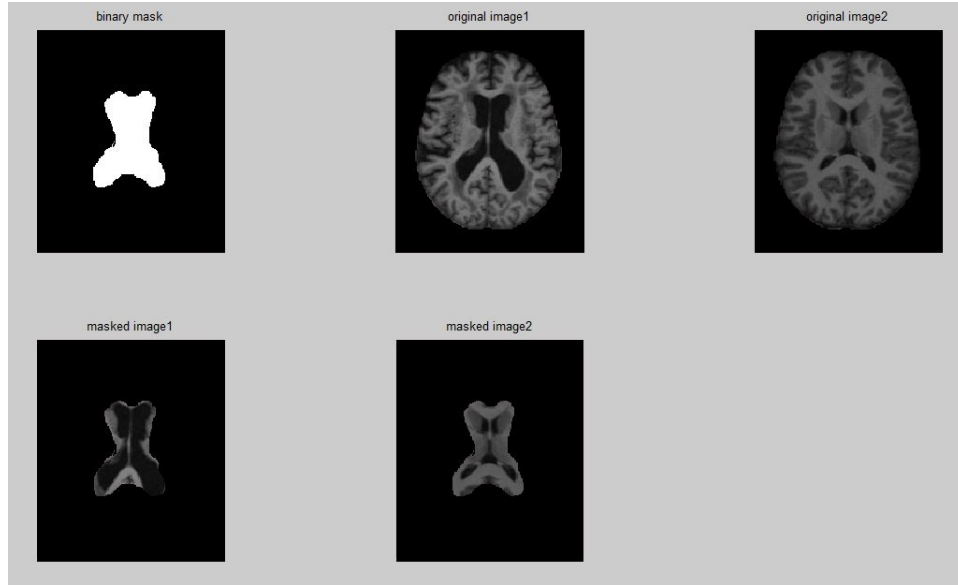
Masked image1 and masked image 2 shows only central region of MRI brain image.
